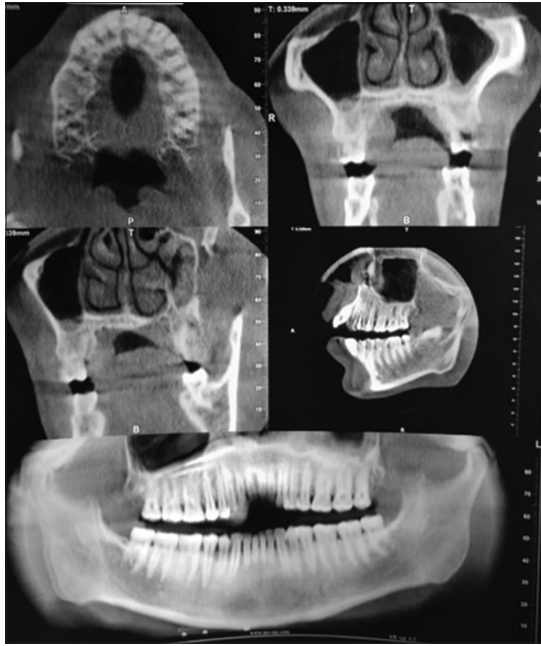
CBCT view showing no bone loss
